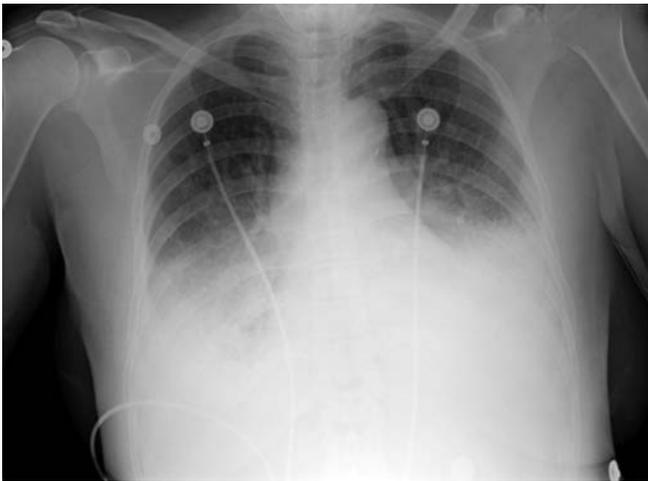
Chest X-ray showing pulmonary edema and bilateral pleural effusions suggestive of congestive heart failure.
